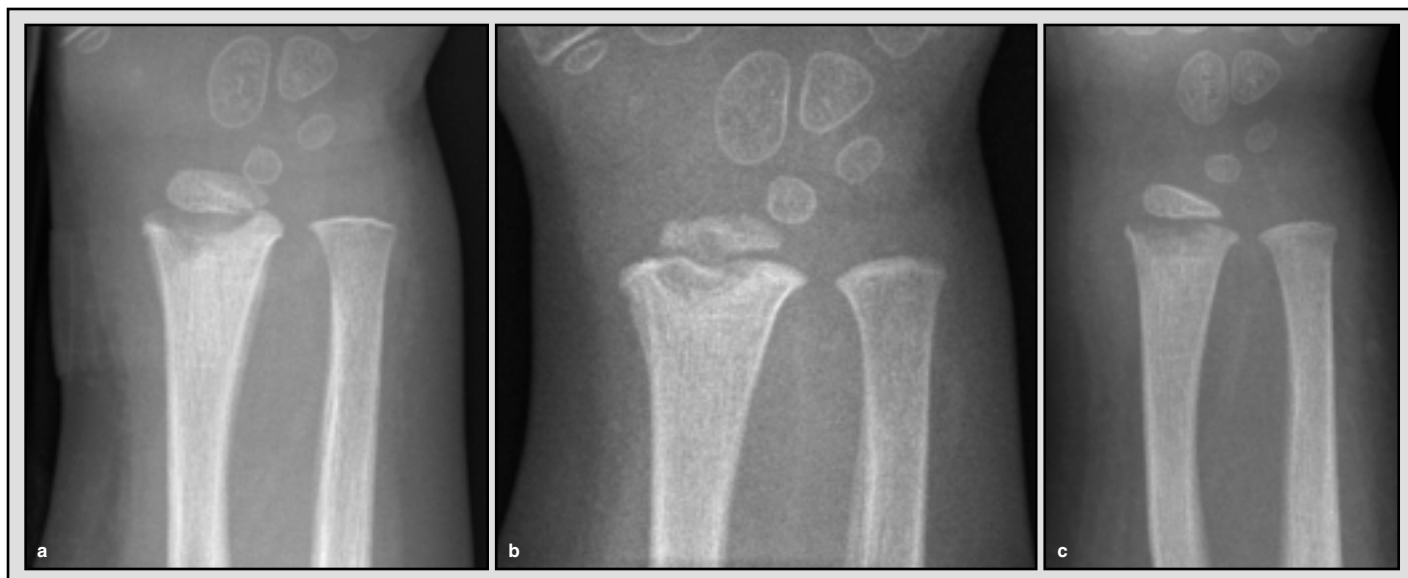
Acute hematogenous osteomyelitis in a 3-year-old girl who presented with pseudoparalysis. Radiographs at presentation (not shown) were normal. Successive plain radiographs show progressive destruction in the distal radius. (a) Two weeks after presentation: erosion of the distal radial metaphysis with loss of fat plane definition. (b) Three weeks after presentation: new bone formation with periosteal reaction. Soft tissue changes less prominent than previous radiograph. (c) Eight weeks after presentation: re-ossification of the distal metaphysis and resolution of soft tissue abnormality.
